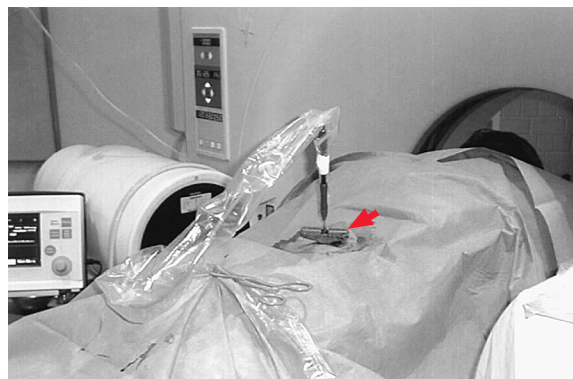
Image of the operative site: the Volume Zoom CT (gantry diameter, 70 cm) leaves enough room to position the C-arm fluoroscope in front of the gantry, allowing the operator to comfortably work in front of the computed tomographic system. The trocar and radiofrequency system (arrow) are placed intratumorally. The patient is positioned prone.
